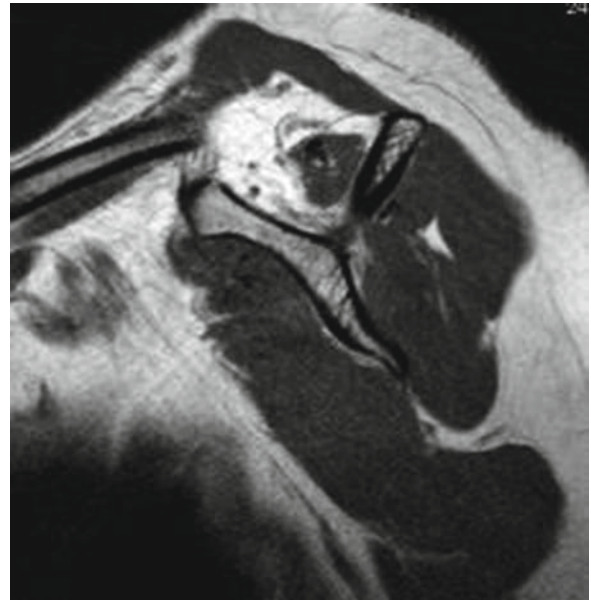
Parasagittal sequence of MRI demonstrating a marked fatty degeneration of the supraspinatus muscle
